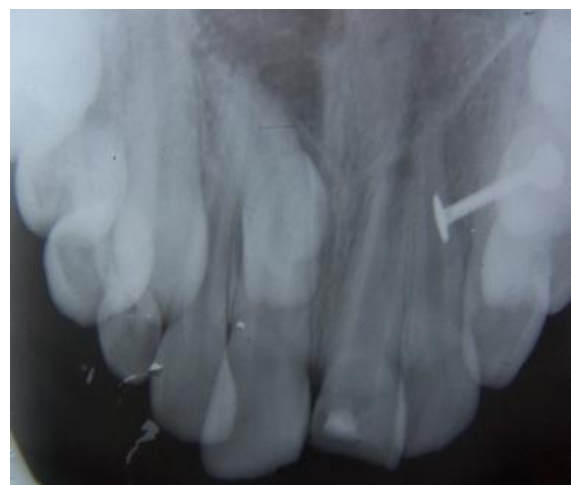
Occlusal radiograph showing open apex in 21 and impacted mesiodens in relation to 11
